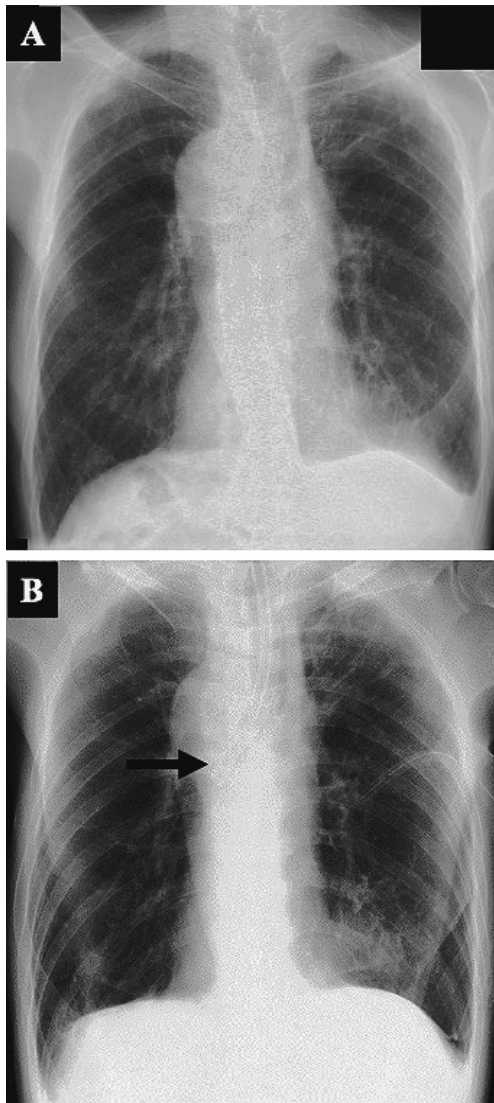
Imaging findings associated with the first surgery. (A) Preoperative X-ray demonstrated situs inversus totalis and tracheal deviation. (B) Postoperative X-ray demonstrated that the bronchial lumen of the DLT (arrow) was appropriately positioned in the right main bronchus.
